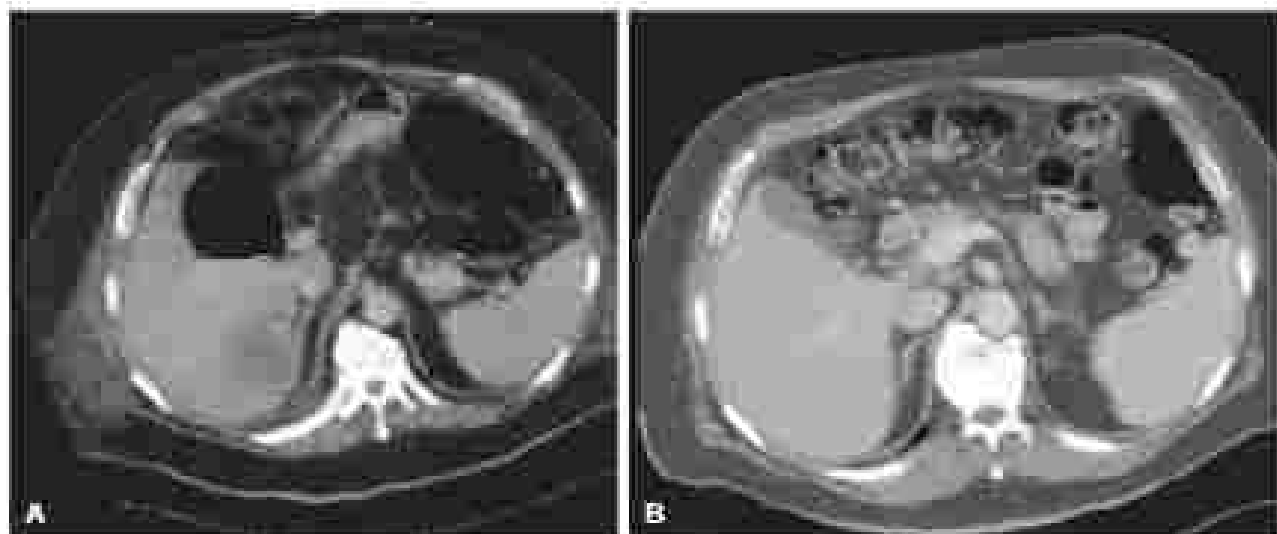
(A) Computed tomography (CT) scan demonstrating a large pyogenic liver abscess (PLA) with an air fluid level in retroperitoneum and (B) CT scan 1 month later in the same patient after achieving complete resolution of the PLA after percutaneous drainage.
